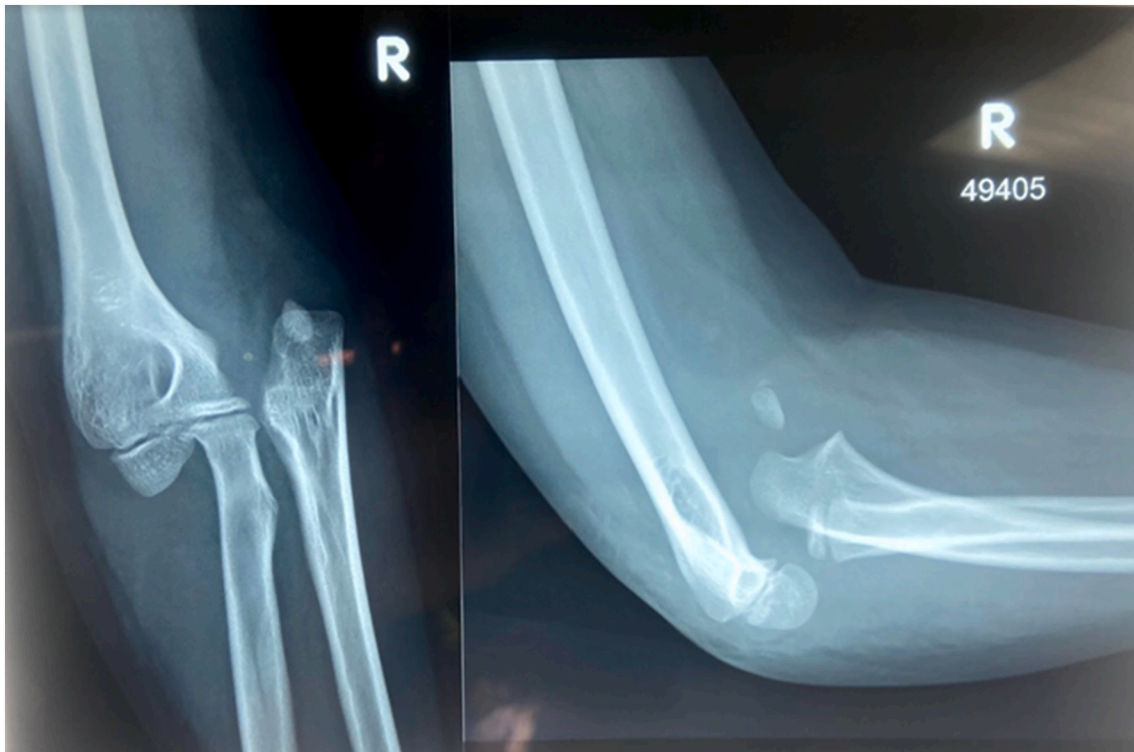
AP and Lateral radiographs of right elbow joint showing anteromedial elbow dislocation with a medial epicondyle avulsion fracture.
